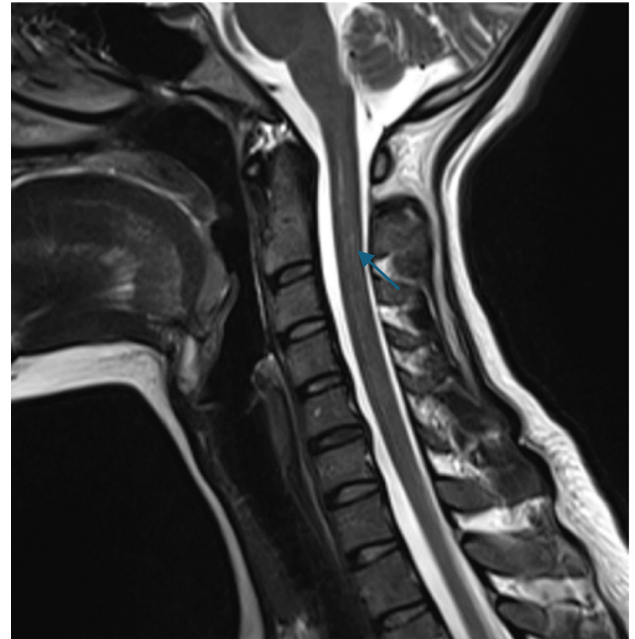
Sagittal view of the cervical MRI with an arrow pointing at a C2 cervical lesion opposite to C2 vertebra.
